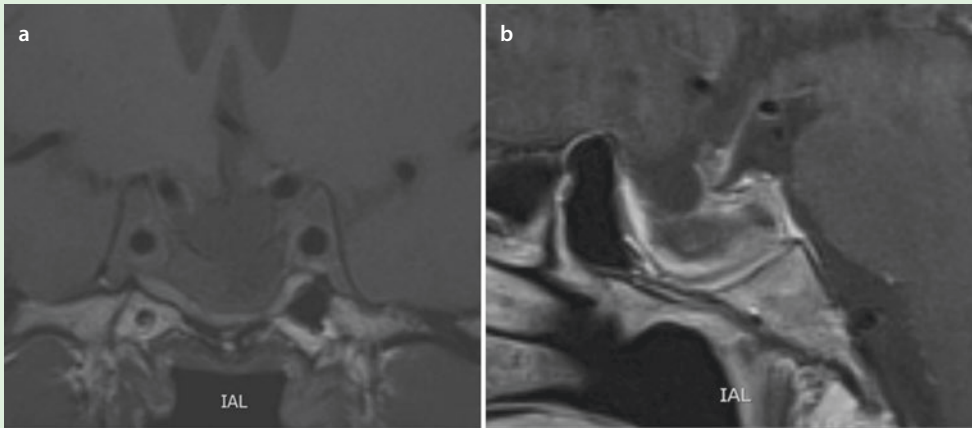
No residual tumor 12 months after the operation on T1-weighted MRI (coronal a and sagittal b slice)
